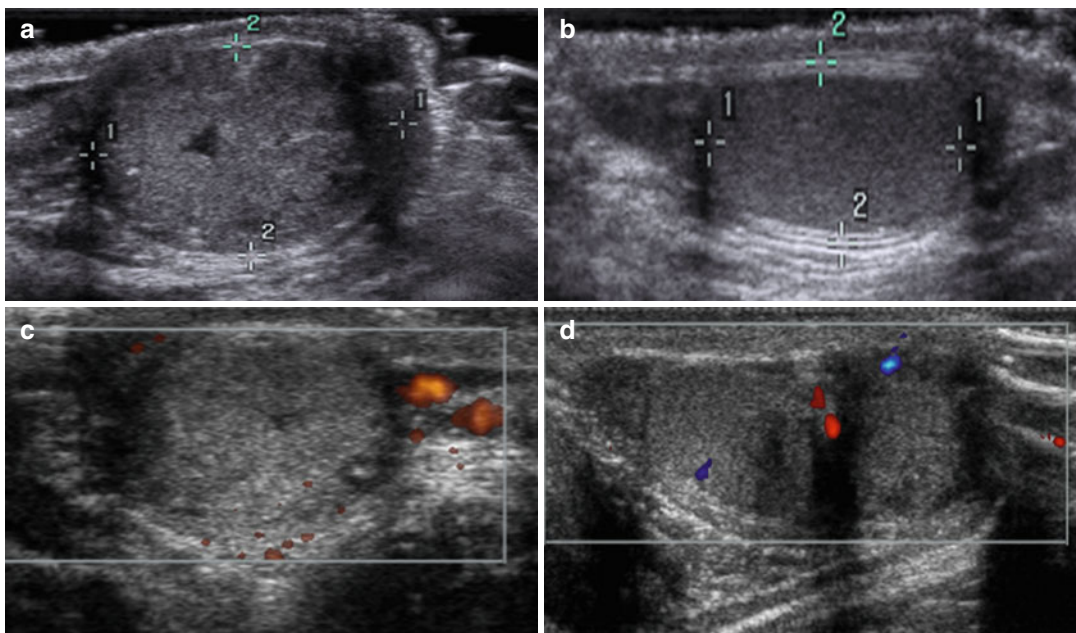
Ultrasound scans in case of testicular tumor; note the oval capsular slightly hyperechogenous formation, with lack of homogeneity and without Doppler flow
